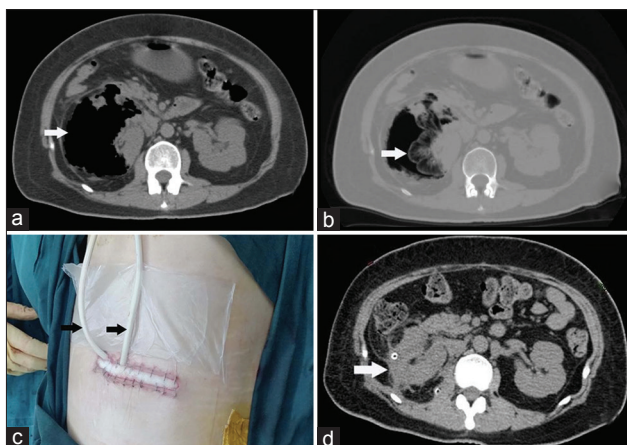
CT showed air densities (arrow) in the perinephric spaces and retroperitoneum, and the kidney was not found (a). The “invisible kidney” (arrow) was detected in the lung window (b). Negative low-pressure VSD (arrows) treatment was conducted in a closed condition (c). The kidney (arrow) recovered after VSD (d). CT: Computed tomography; VSD: Vacuum sealing drainage.
